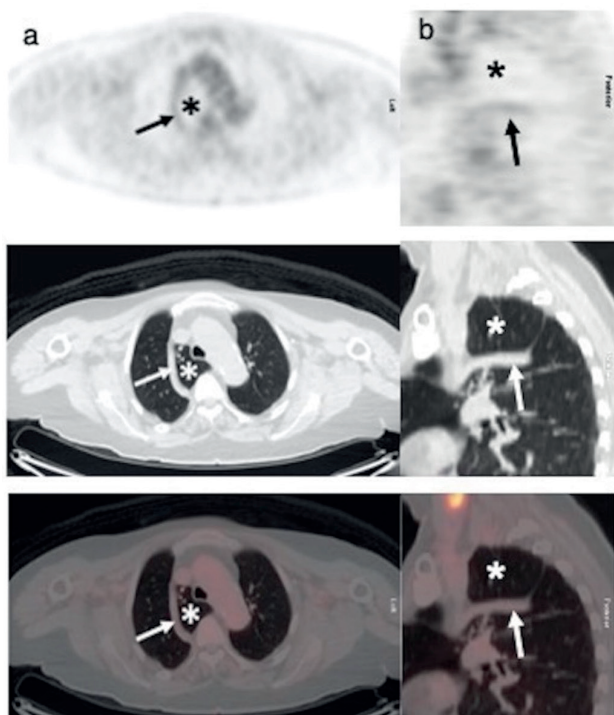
Axial (a) and sagittal (b) images of a ¹⁸F- fluorodeoxy-glucose positron emission tomography/computed tomography (CT) scan of a 74-year-old female with a history of multiple malignancies (breast cancer, thyroid cancer and non-Hodgkin's lymphoma) shows an azygous lobe (asterisk), bounded by an azygous fissure (solid arrow) in the right upper lung. Note minimal increased uptake along the course of the azygous fissure.
